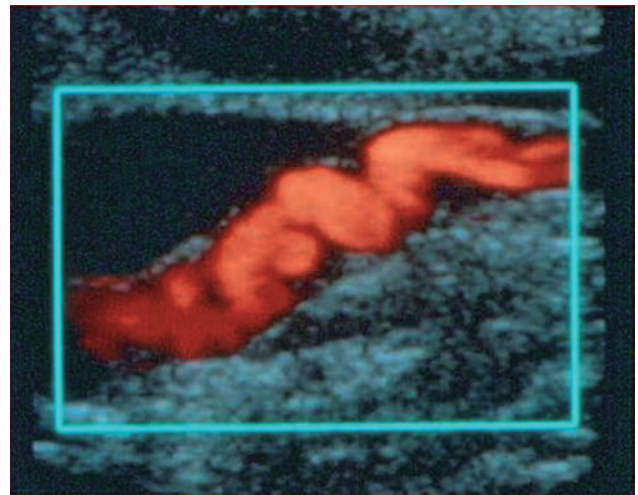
Power Doppler image of an internal carotid artery with fibromuscular disease. The classic “string of beads” appearance was easily recognized in this patient.
